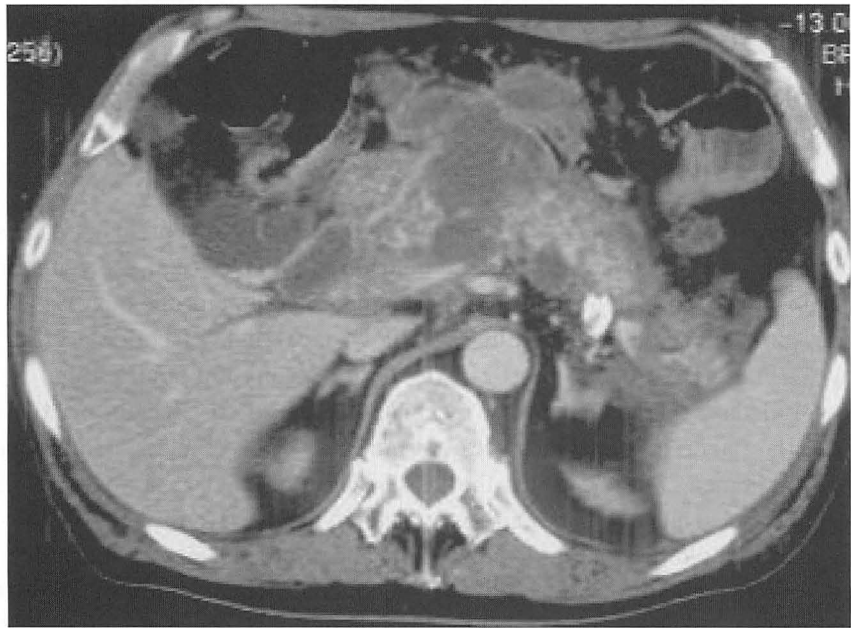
Abdominal enhanced CT on day 21 showed swollen pancreas, fluid collection, and a pseudocyst. It was inferred to be severe inflammation because pancreatitis involved organs around the pancreas.
